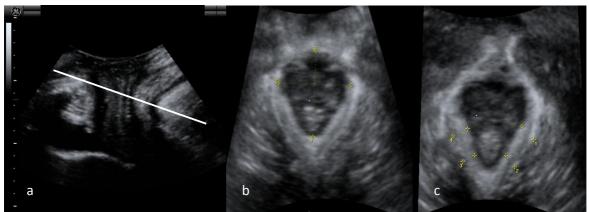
Translabial pelvic floor ultrasound, in mid-sagittal showing the location used for determining the minimal hiatal dimensions (a); levator hiatus area, AP and lateral diameter at rest and Valsalva (b): measurement of pubovisceral muscle thickness at rest (c).
